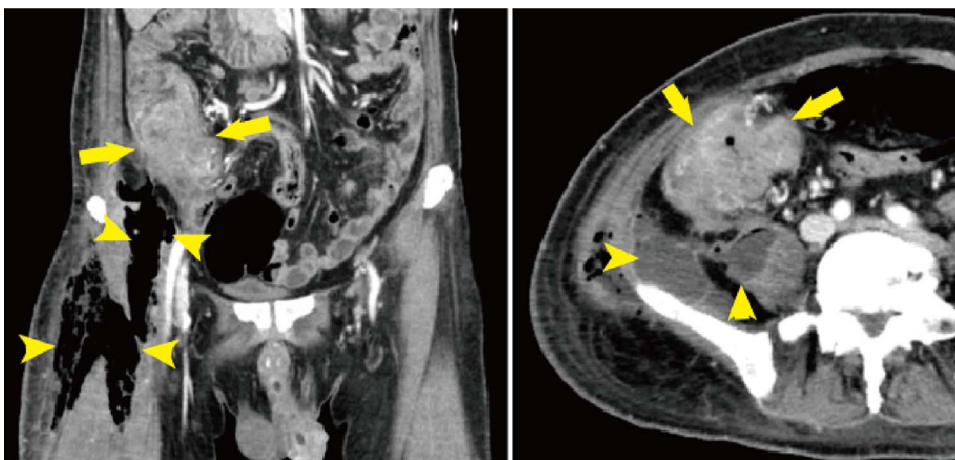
Abdominal computed tomography (CT) revealed ascending colon tumor (arrows), free air through the abdominal cavity to the intra muscular space of the right thigh, and fluid collection in the retroperitoneal cavity and psoas muscle (arrow heads).
